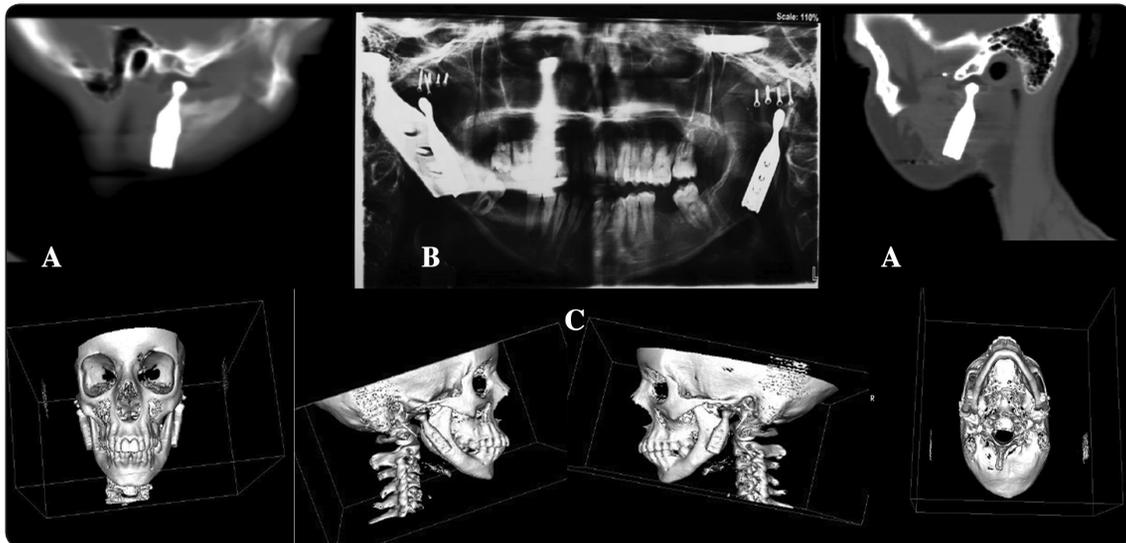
Postoperative radiographs. (A) 3-year postoperative Sagittal CT cuts; (B) Immediate postoperative panoramic radiograph; (C) 3-years postoperative 3D reformatted cuts (lower panel)
